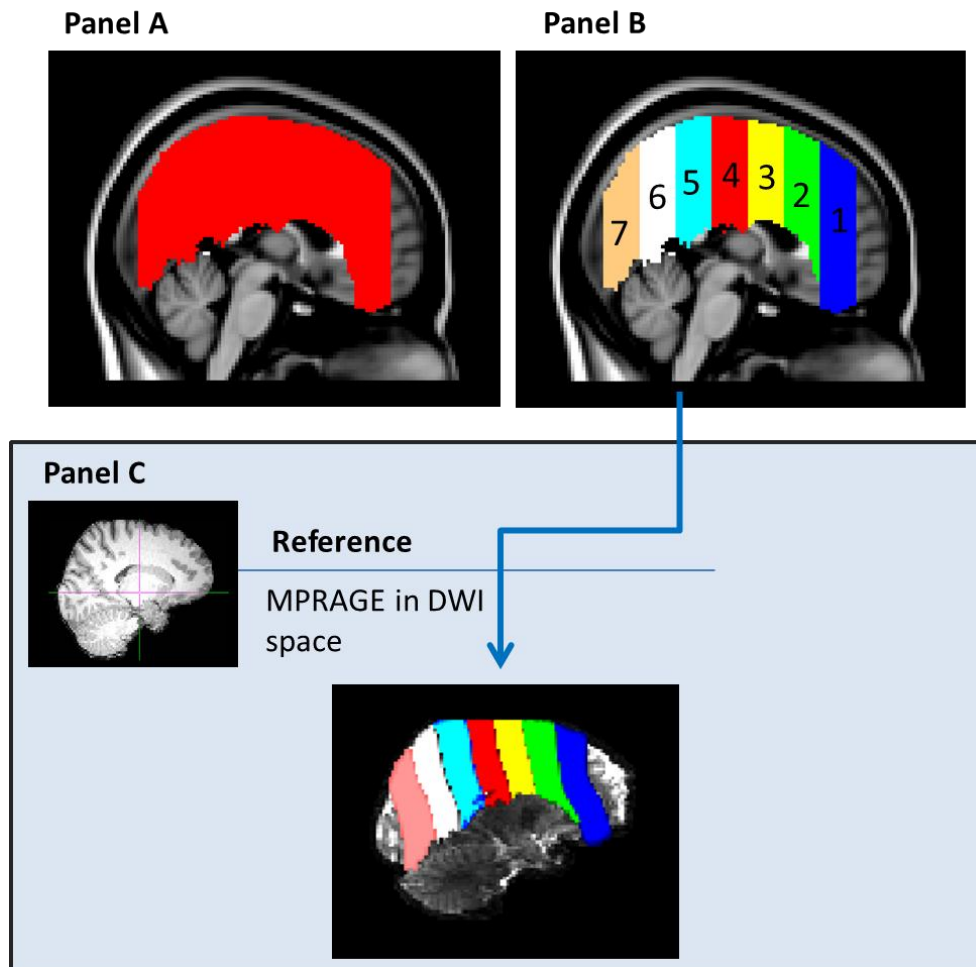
Sagittal view of the neocortex ROI defined in a MNI stereotactic coordinate space (panel A). To analyse age differences, neocortex ROI is subdivided on 7 sub-regions (panel B). The neocortex ROI are converted to each individual subject DWI space using the transformation matrix resulted on the registration of the MNI template to the MRAGE subject images previously converted to the DWI's space (panel C).
